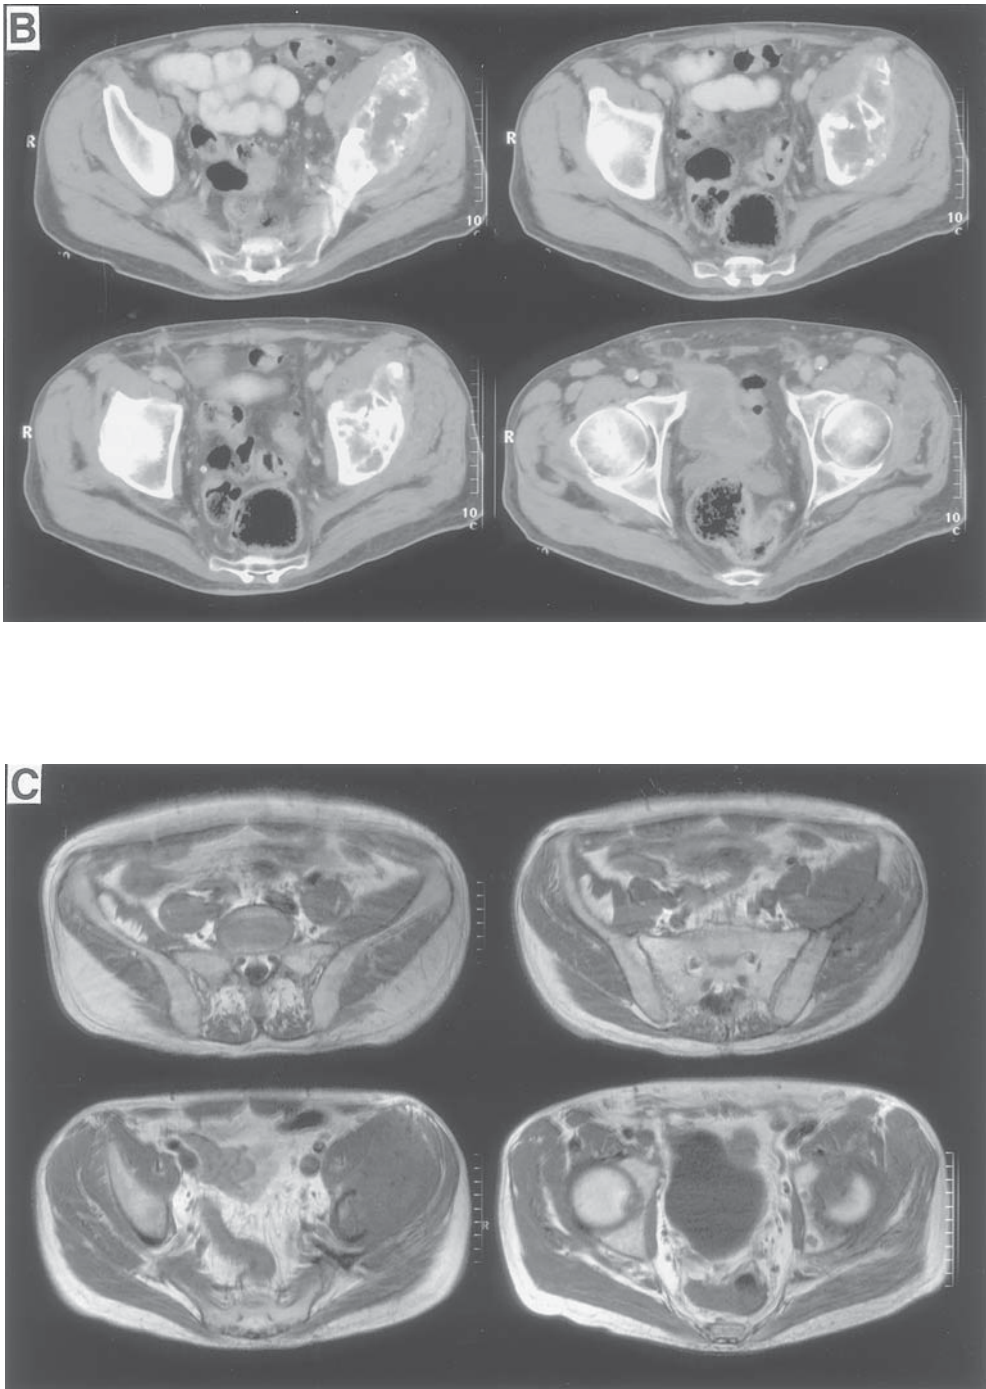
(Continued). (B) CT scan showing a destructive pelvic lesion that involves the dome of the hip joint. (C) Large soft-tissue mass with involvement of the hip joint being quite evident on MRI.
